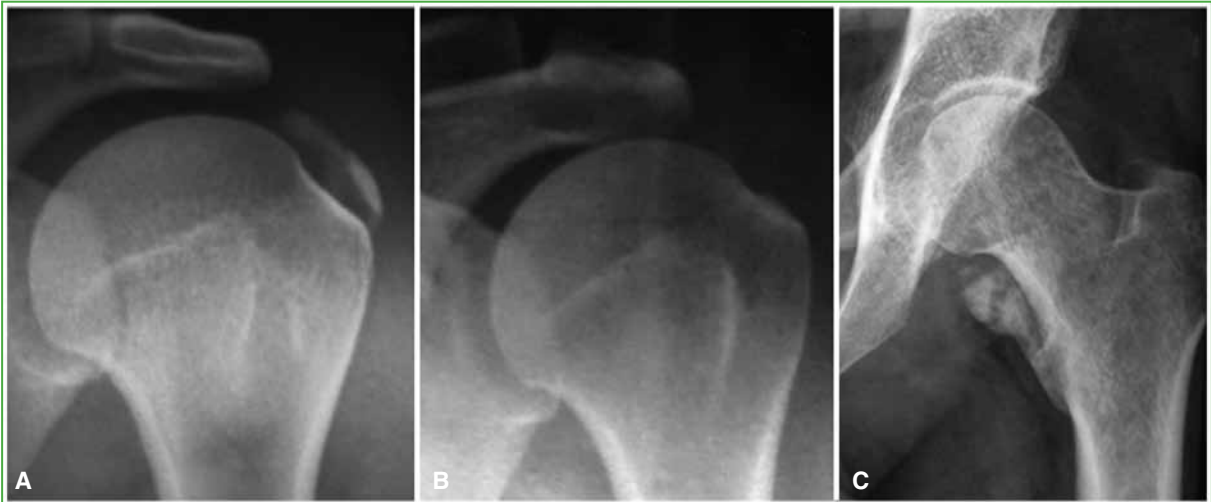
Plain radiographs of the shoulder, AP view, showing calcification of the supraspinatus tendon (A) and the same case after a focused shockwave treatment plan (B). C. Radiograph of the hip, AP view. Heterotopic ossification of the hip is seen after a stay in intensive care for COVID-19.
